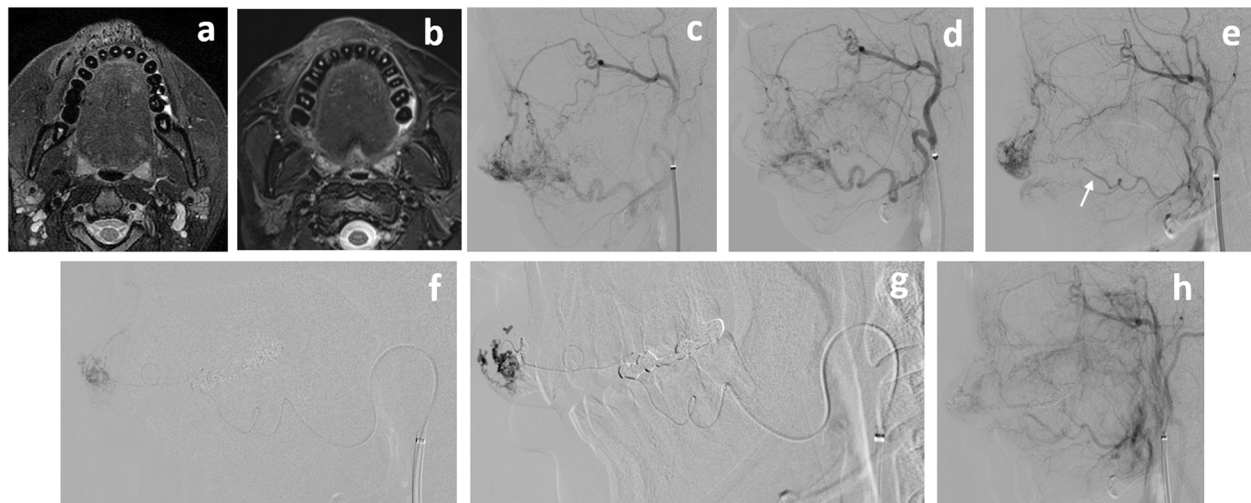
Angiogram in Case 2 showing high-flow AVMs in the right upper lip that were fed mainly by mainly bilateral SLab As from bilateral FAs and which drained into the right facial and angular veins. The lesion was diagnosed in accordance with Cho's classification as type IIIa AVM. (a) Fat-saturated T2WI MRI showing high-signal intensity with multiple flow voids in the upper lip before treatment. (b) Fat-saturated T2WI MRI 3 months after the last embolization session showing regression of the soft tissue swelling and disappearance of the flow voids. (c) Right external carotid arteriogram, lateral view, before the first embolization session. (d) Right external carotid arteriogram showing partial devascularization of the AVM after embolization of the right SLab A during the first session. (e) Left external carotid arteriogram, lateral view, before the second embolization session showing residual AVMs fed by the SLab A (white arrow). (f) The microcatheter was navigated into the distal feeder from the left SLab A in the second embolization session. (g) Angiogram, lateral view, showing the nBCA injection under flow control. The nBCA-lipiodol mixture filled the shunting points and the distal draining veins. (h) Left external carotid arteriogram showing that the AVMs near-completely disappeared after embolization of the left SLab A during the second session
